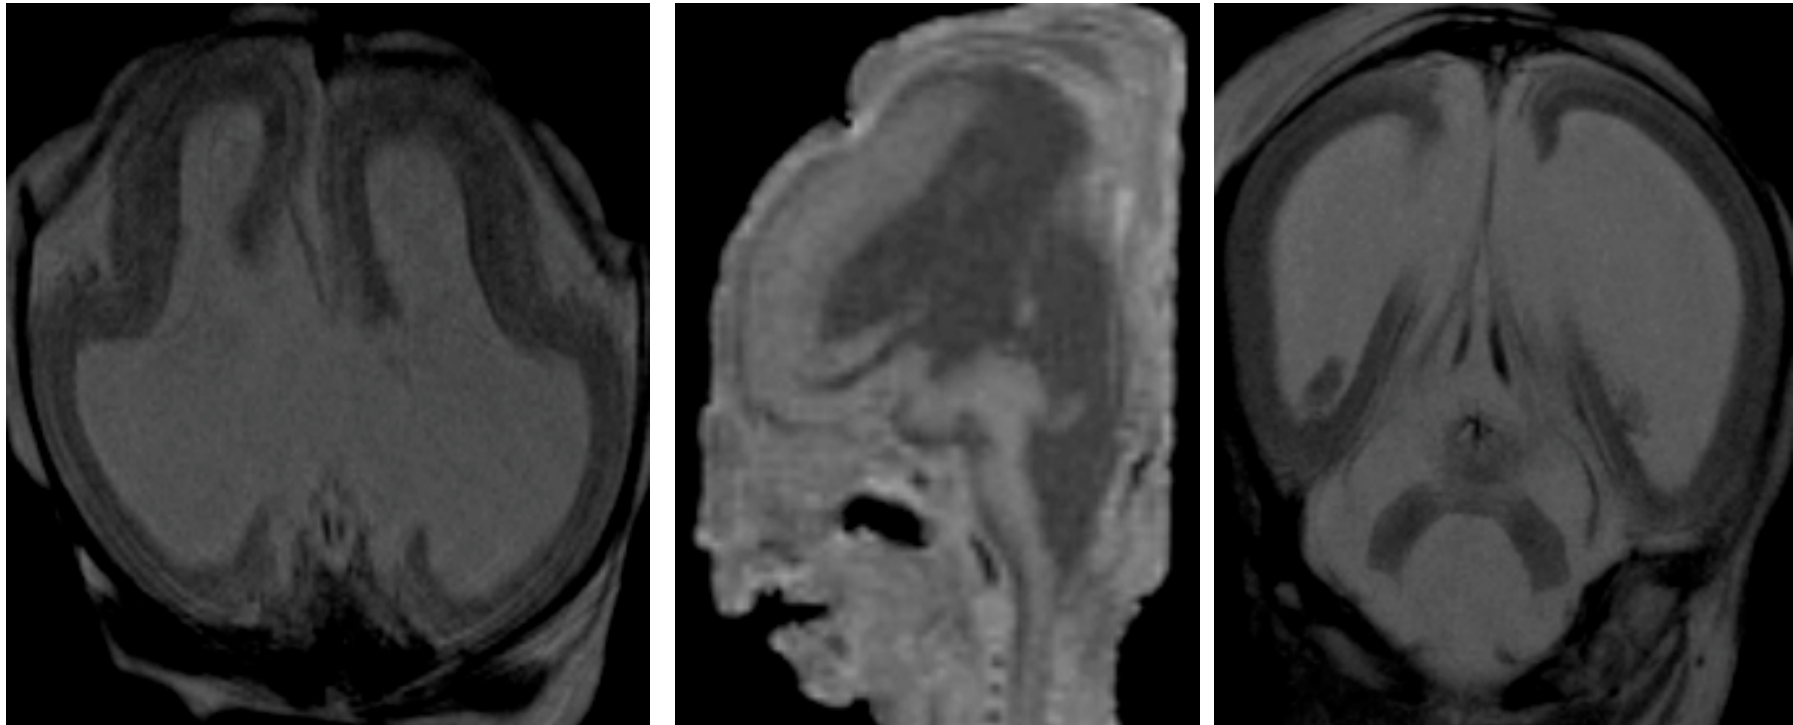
Comparison of antenatal and post-mortem MR imaging
